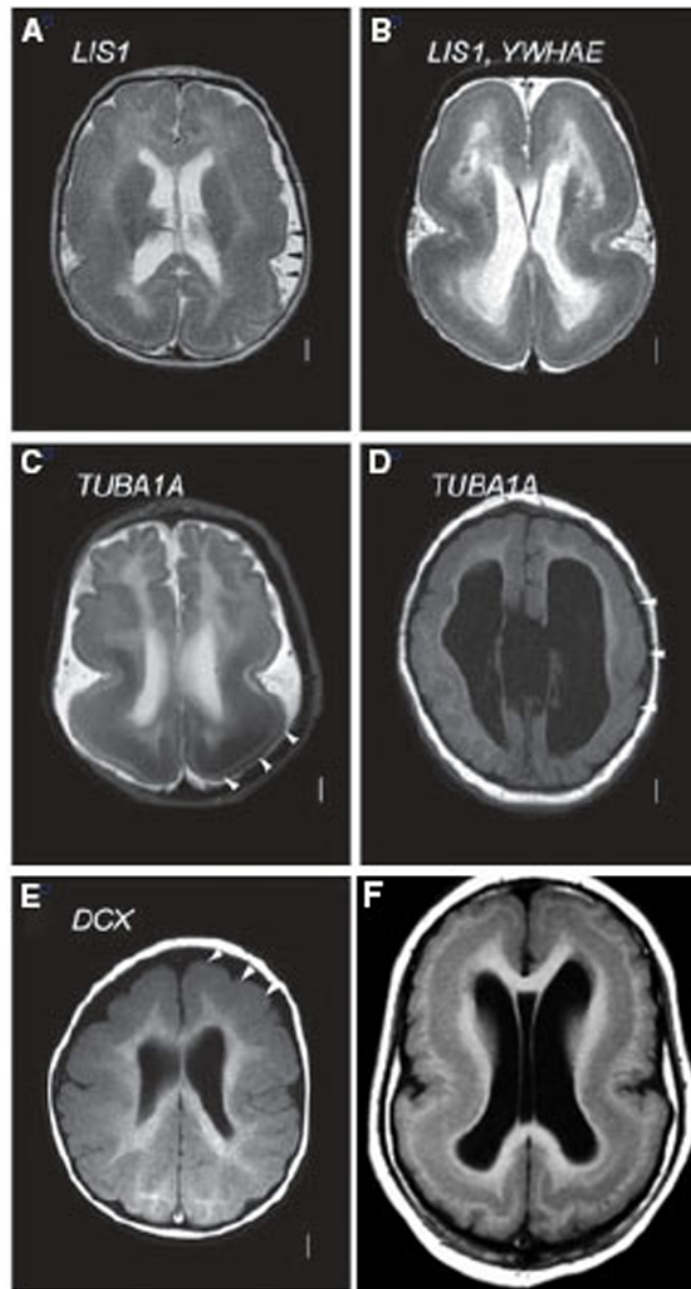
MRI of lissencephaly caused by microtubule pathway genes. High axial magnetic resonance images of lissencephaly (LIS) associated with mutations in microtubule related genes. Arrowheads on the axial images mark the most severely involved brain regions. (A) Classic LIS, with posterior more severe than anterior ($p > a$) gradient associated with an intragenic mutation of LIS1. (B) Severe classic LIS due to deletion 17p13.3 that results in loss of LIS1, YWHAE, and all of the intervening genes in a child with Miller-Dieker syndrome. (C) Classic LIS with a $p > a$ gradient caused by an intragenic mutation of TUBA1A. (D) Moderate severity lissencephaly with cerebellar hypoplasia (LCH) with complete agenesis of the corpus callosum, large dysplastic midbrain and tectum, and severe cerebellar hypoplasia associated with another intragenic mutation of TUBA1A. (E) Classic LIS with anterior more severe than posterior ($a > p$) gradient caused by an intragenic mutation of DCX. Adapted from *Epilepsia* 51: Dobyns, WB. The clinical patterns and molecular genetics of lissencephaly and subcortical band heterotopia, 5-9, Copyright (2010), with permission from Wiley. Panel F shows the MRI of a 15-year-old girl with a severe subcortical band heterotopia due to a DCX mutation. Reprinted from *Neurobiology of Disease*, 38(2): Guerrini R, Parrini E, Neuronal migration disorders, 154-66, Copyright (2010), with permission from Elsevier.
